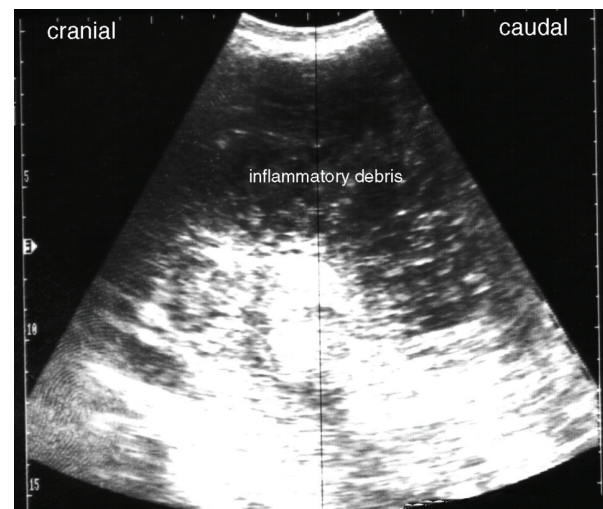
Sonogram of a buffalo with acute diffuse peritonitis with hypoechoic exudate interspersed with echogenic fibrinous strands (3.5 MHz)
